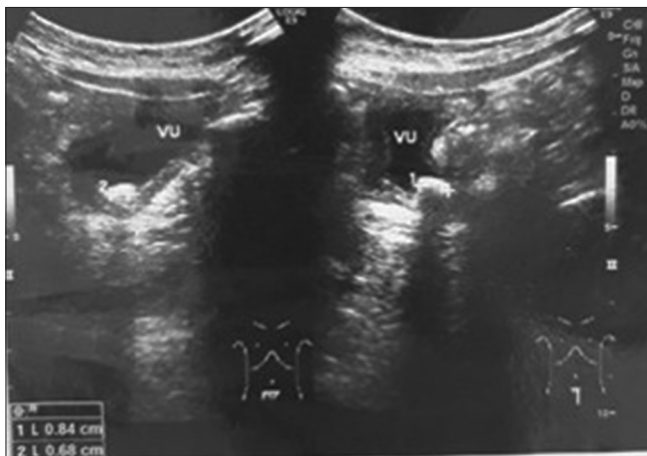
Bladder ultrasound
